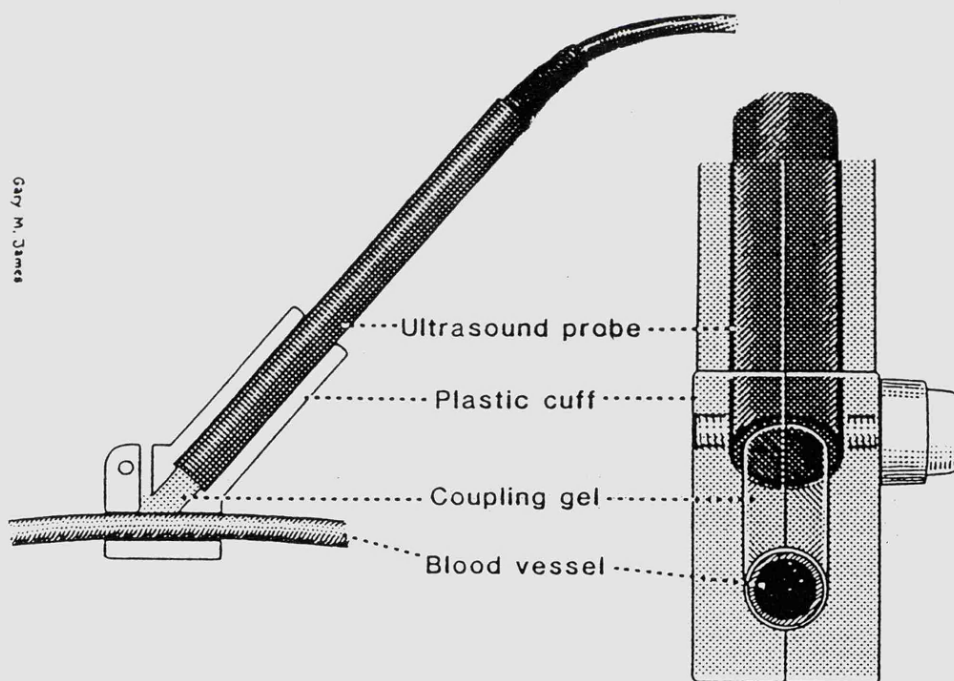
Doppler pencil probe in an acrylic cuff.
